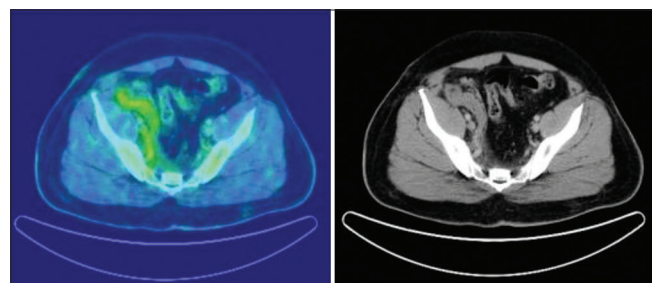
Fascial thickening and haziness with soft tissue density noted in the right pelvic retroperitoneum extending along the right lateral pelvic wall (SUVmax 12.80); maximum thickness 19 mm. Haziness and fat stranding is noted in the adjacent mesentery and mesorectal fat. Biopsy from retroperitoneum did not show abnormalities. Final diagnosis was cutaneous small vessel vasculitis. (False positive positron emission tomography-computed tomography scan)
